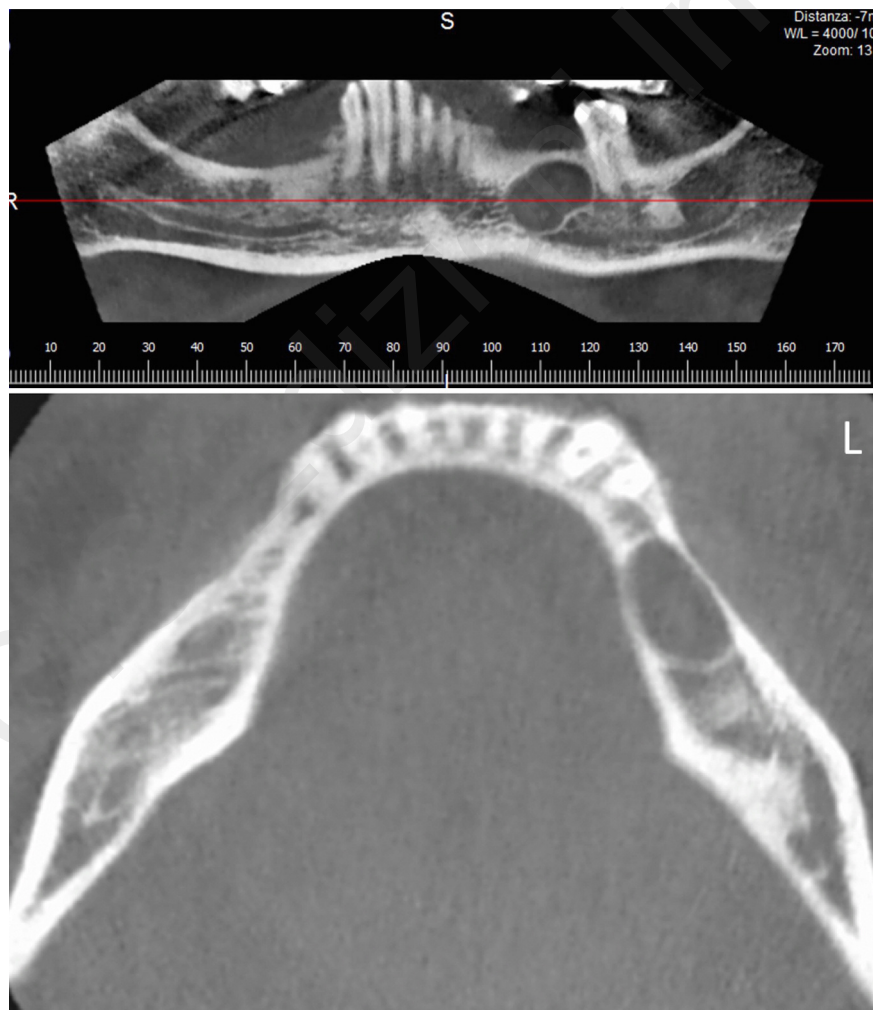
Panoramic view (a) and axial view (b) obtained from the preoperative CBCT. An unilocular radiolucent area is detectable in the posterior left mandible in close proximity to the mandibular canal and mental foramen.
